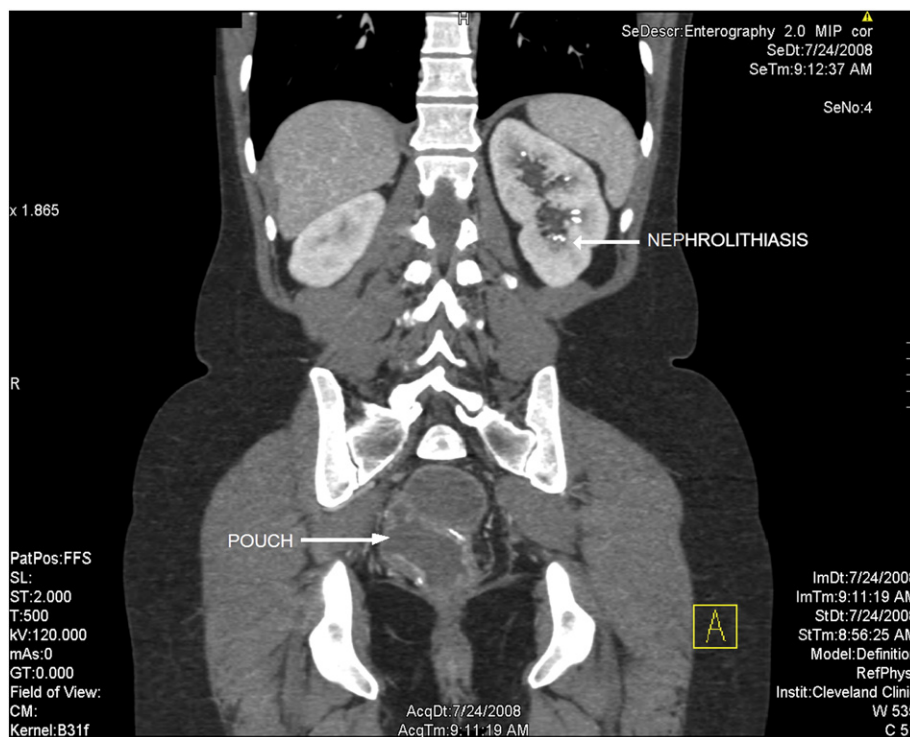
CT abdomen image showing nephrolithiasis in a patient with an ileal pouch.
